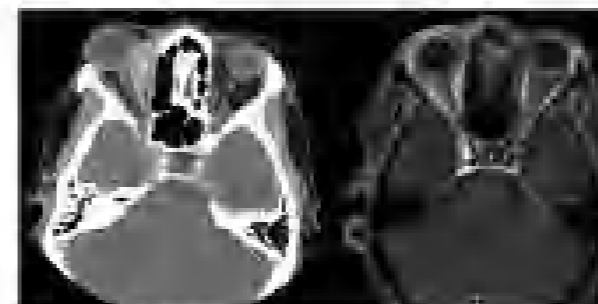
Axial CT scan of a retrobulbar medial orbital mass, well-circumscribed with anterior bowing (asterisk), extending posteriorly along the medial orbital wall (arrow) and displacing the medial rectus muscle (dot). The mass was completely debulked with the aid of an ultrasonic aspirator (Styker Corporation) prior to initiation of adjuvant chemotherapy near complete debulking of the mass.
